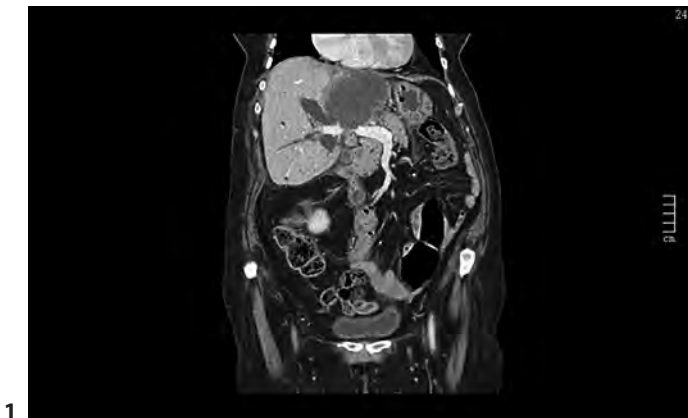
Abdominal CT before the procedure.
